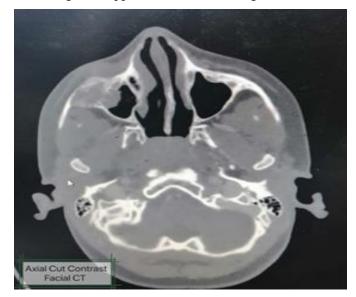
Axial cut of Brain CT with IV contrast, (Bone window). There is expansile lytic bone lesion with enhancing soft tissue mass arising from in ferio-lateral aspect of the right orbital wall, causing bone destruction of inferior orbital wall and right zygomatic bone
